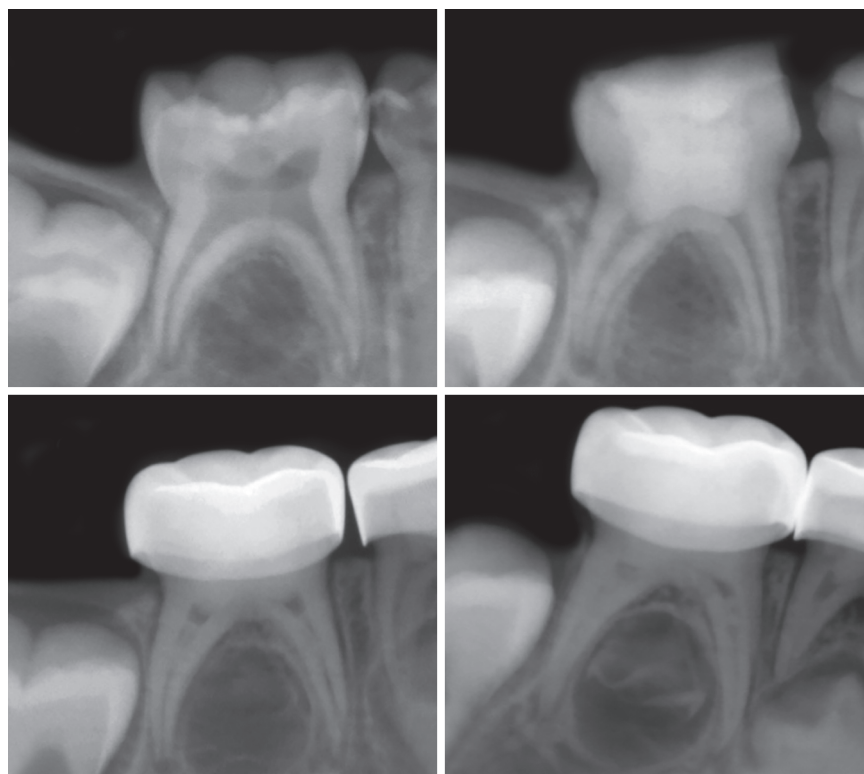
Preoperative and postoperative periapical radiographs of mandibular second primary molar treated with Biodentine™ pulpotomy. (t-1) Preoperative radiograph; (t 0) postoperative radiograph taken immediately after Biodentine™ pulpotomy; (t 1) 6-month follow-up periapical radiograph showing PCO, Root Edification; (t 2) 12-month follow-up periapical radiograph with PCO, root development with AC
